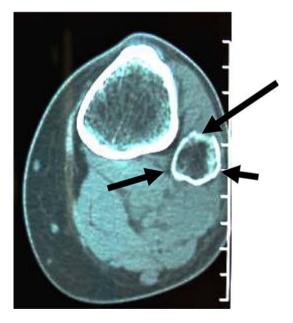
Axial CT scan through the left extremity demonstrating an expansible soft-tissue mass indicated by arrows in the fibula
